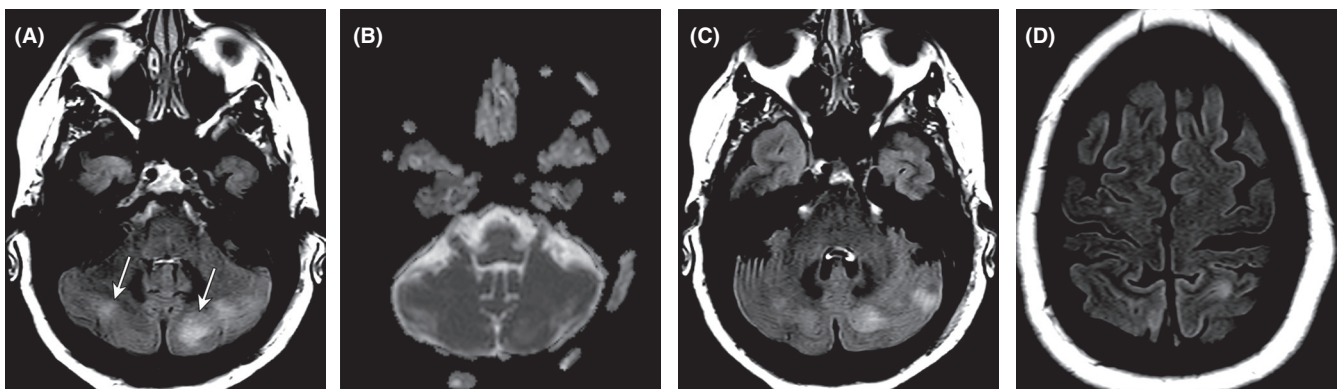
Magnetic resonance imaging of the brain. (A) Subcortical areas of white matter involvement with increased fluid-attenuated inversion recovery (FLAIR) signal (arrows) in bilateral cerebellar cortex. (B and C) Corresponding diffusion-weighted imaging (DWI) and apparent diffusion coefficient (ADC) demonstrating no restricted diffusion with no contrast enhancement. (D) Few areas of edema involving bilateral subcortical white matter in parietal lobes with worse involvement in the cerebellum
